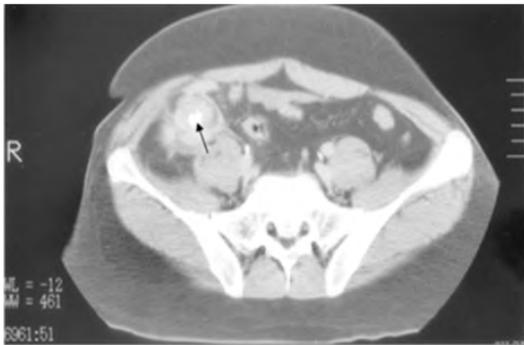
A radiopaque material was found within the appendix, arrow (Computed tomography).
